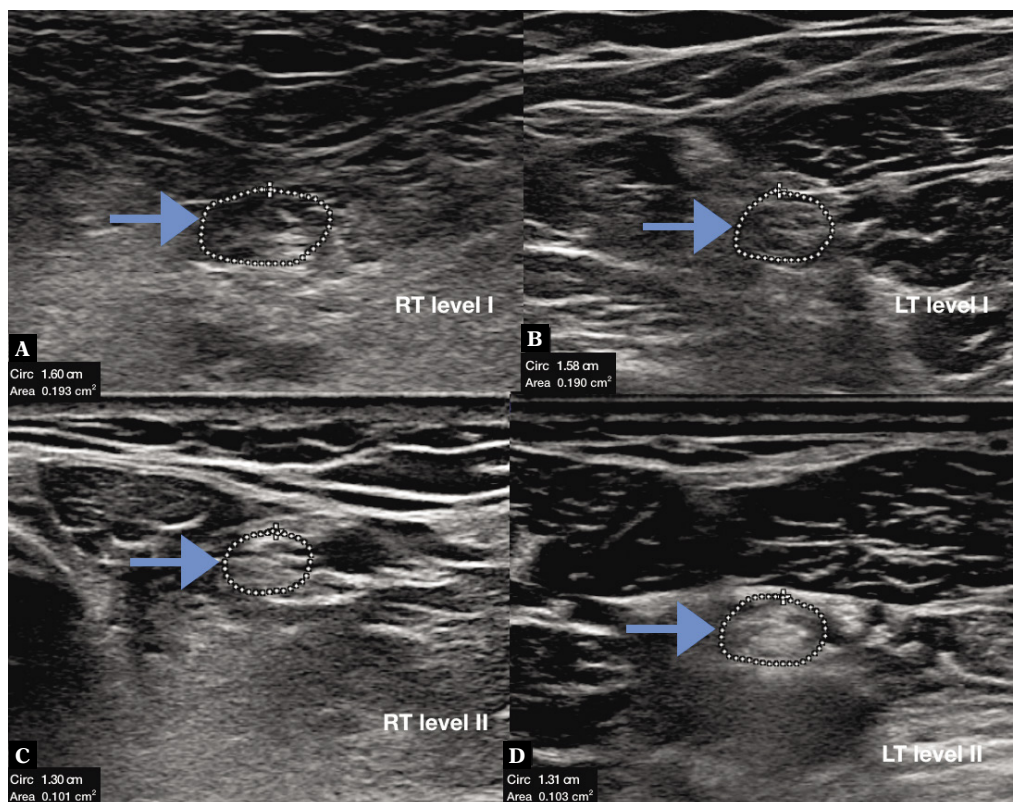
High resolution ultrasonography of normal tibial nerve at level I (A, B) and II (images C, D) in left lower limb in 42 years old male weighing 63 kg, having height of 168 cm and body mass index of 22.3. Mean cross sectional area was 0.193 cm² and 0.190 cm² at level I and 0.101 cm² and 0.103 cm² at level II. (RT – right, LT – left, arrow – tibial nerve)
